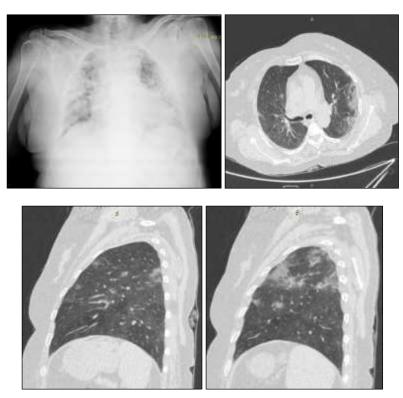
A 60 years' old female, characterized as "moderate" on CXR (8/12); from HRCT- CT severity score (9/25)-characterized as "moderate"; images from top right- clockwise- CXR (PA view); axial, right and left sagittal HRCT
